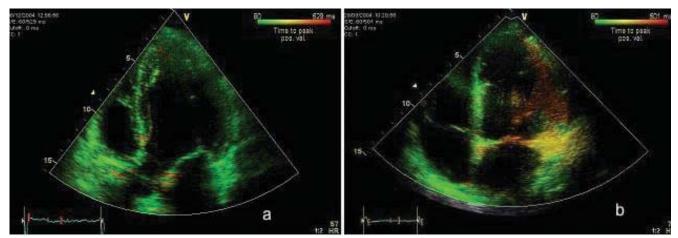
Tissue synchronisation imaging. (a) Apical 4-chamber view demonstrating normal time to peak velocity data (colour coded green). (b) Apical 4-chamber view demonstrating significant lateral wall delay as shown in red with no significant delay seen in septal region.
